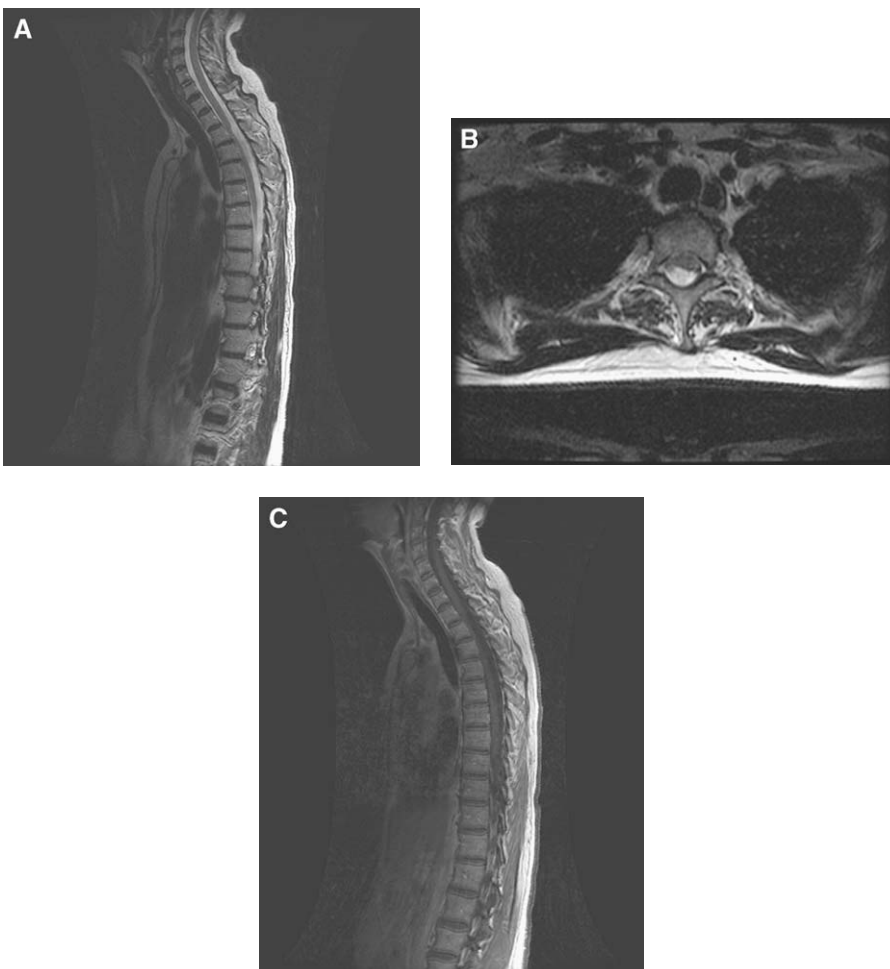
(A and B) Sagittal and axial T2-weighted images demonstrate anterior and left lateral displacement and compression of the upper thoracic cord by an intradural extramedullary lesion with signal intensity characteristics of cerebrospinal fluid (an arachnoid cyst, likely resulting from adhesions in the subarachnoid space). This could alternatively represent adhesion/cord tethering/cord herniation. (C) Gadolinium-enhanced sagittal T1-weighted image reveals no pathologic enhancement.
